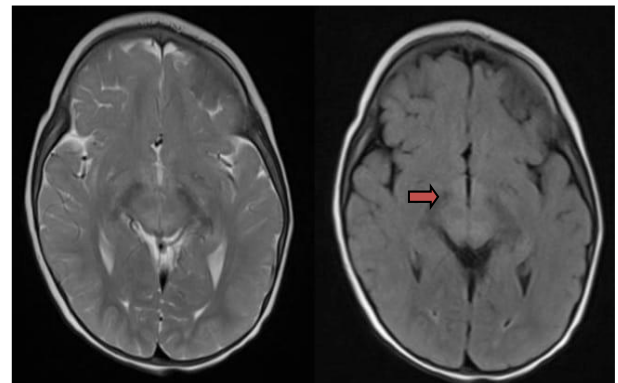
MRI brain-hyperintense lesions in midbrain, brainstem, visualized cervical spine.
